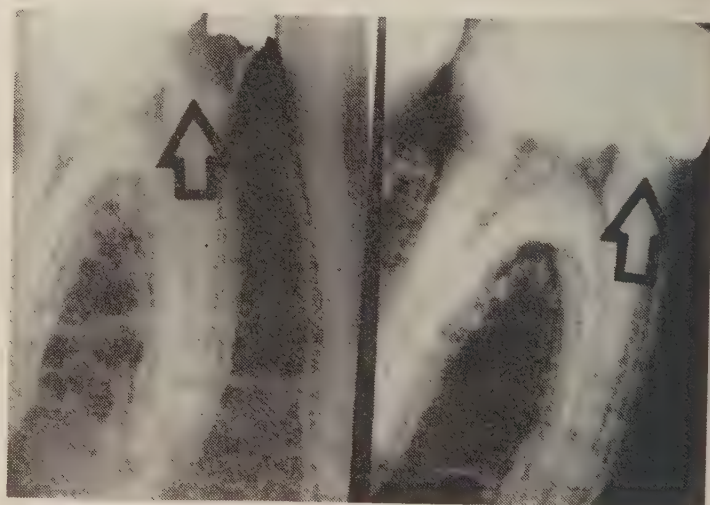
Left: radiograph of mandibular right first molar of a 16 year old patient with an active carious lesion beneath a silver amalgam restoration. Right: the same tooth one year after indirect pulp capping. The extent of apparent remineralization (arrow) appears identical to that seen at three months.
